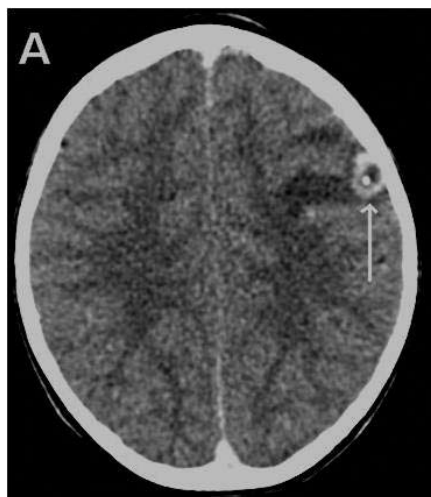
A CT scan showing neurocysticercosis with a calcified nodule representing a scolex, and surrounding oedema.
